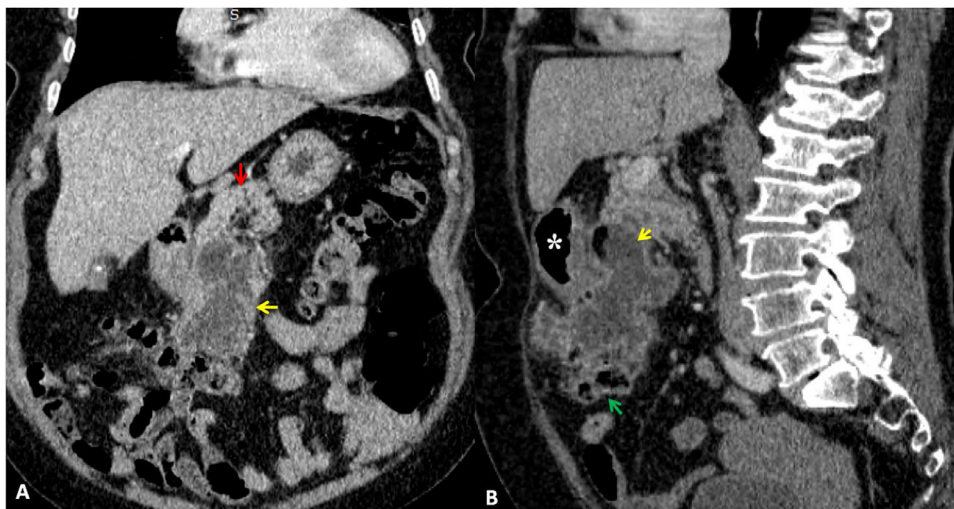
Coronal (A) and sagittal (B) enhanced computed tomography of the abdomen showing the necrotic peritoneal mass (yellow arrow) adherent to adjacent structures such as the transverse colon (green arrow), pancreas (red arrow) and the stomach (*).
